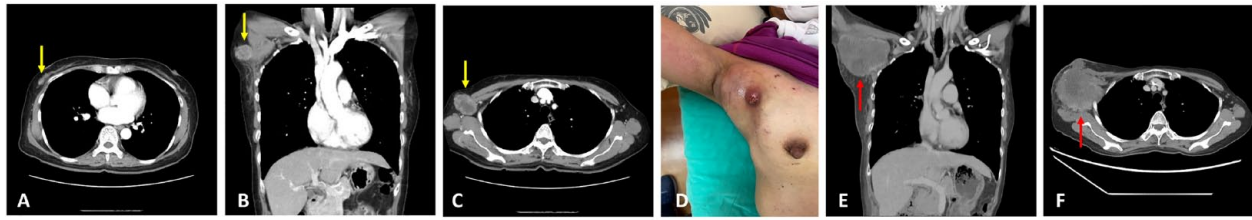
(A-C) Representative CT images scanned at first diagnosis (August 2022). (A) Axial view showing a 0.6-cm tumor (yellow arrow) at the right lower out quadrant of the breast. (B) Coronal and (C) axial views showing right-sided axillary breast cancer (yellow arrow). (D) Clinical photograph taken at the time when the patient was referred to our clinic (February 2023). A solitary and pedunculated mass was seen in the upper external quadrant of the right breast. (E and F) Representative CT images of the (E) coronal and (F) axial views showing an enlarged breast cancer, unresponsive to chemotherapy and immunotherapy (February 2023). CT indicates computed tomography.
